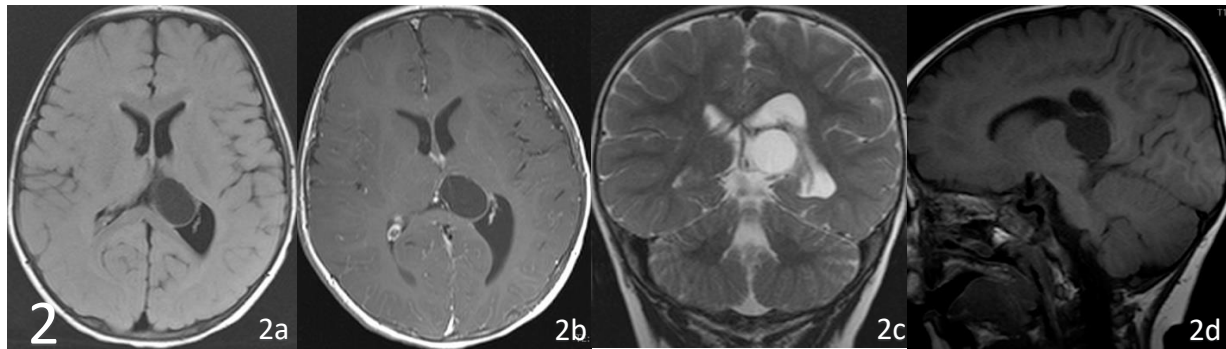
MRI performed one year later showing noted shrinking in size of the cyst
